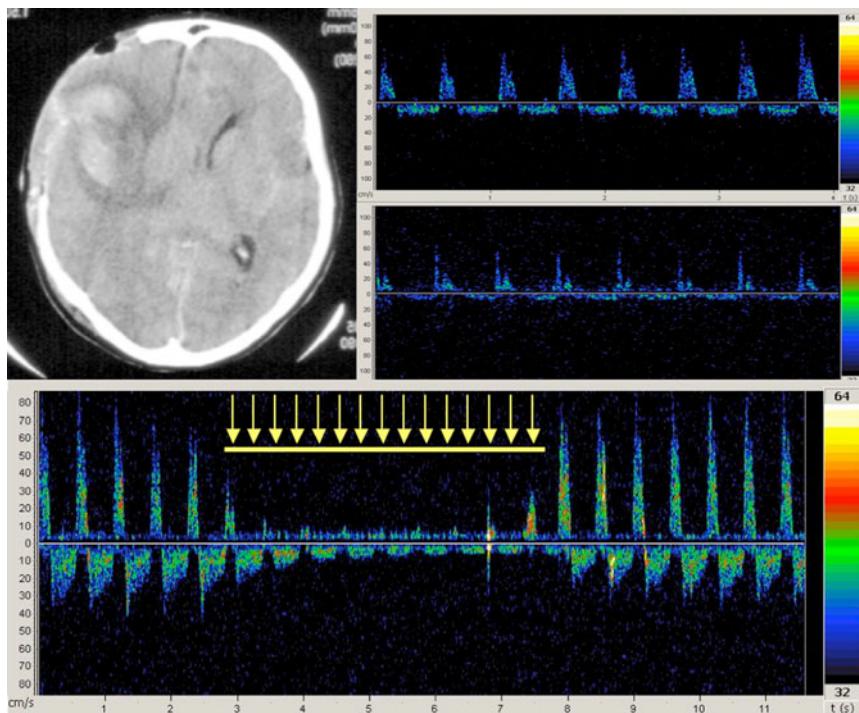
Cerebral CT scan (top left) and transcranial Doppler (TCD) findings (top right) in case 1. Cerebral CT shows the extensive intraparenchymal hemorrhage with the right decompressive craniectomy, and TCD shows the typical pattern of absence of cerebral blood flow. Short compression on the dural expansion (yellow arrows, bottom) induces the further disappearance of TCD signal, which promptly returns to basal conditions once compression is removed
